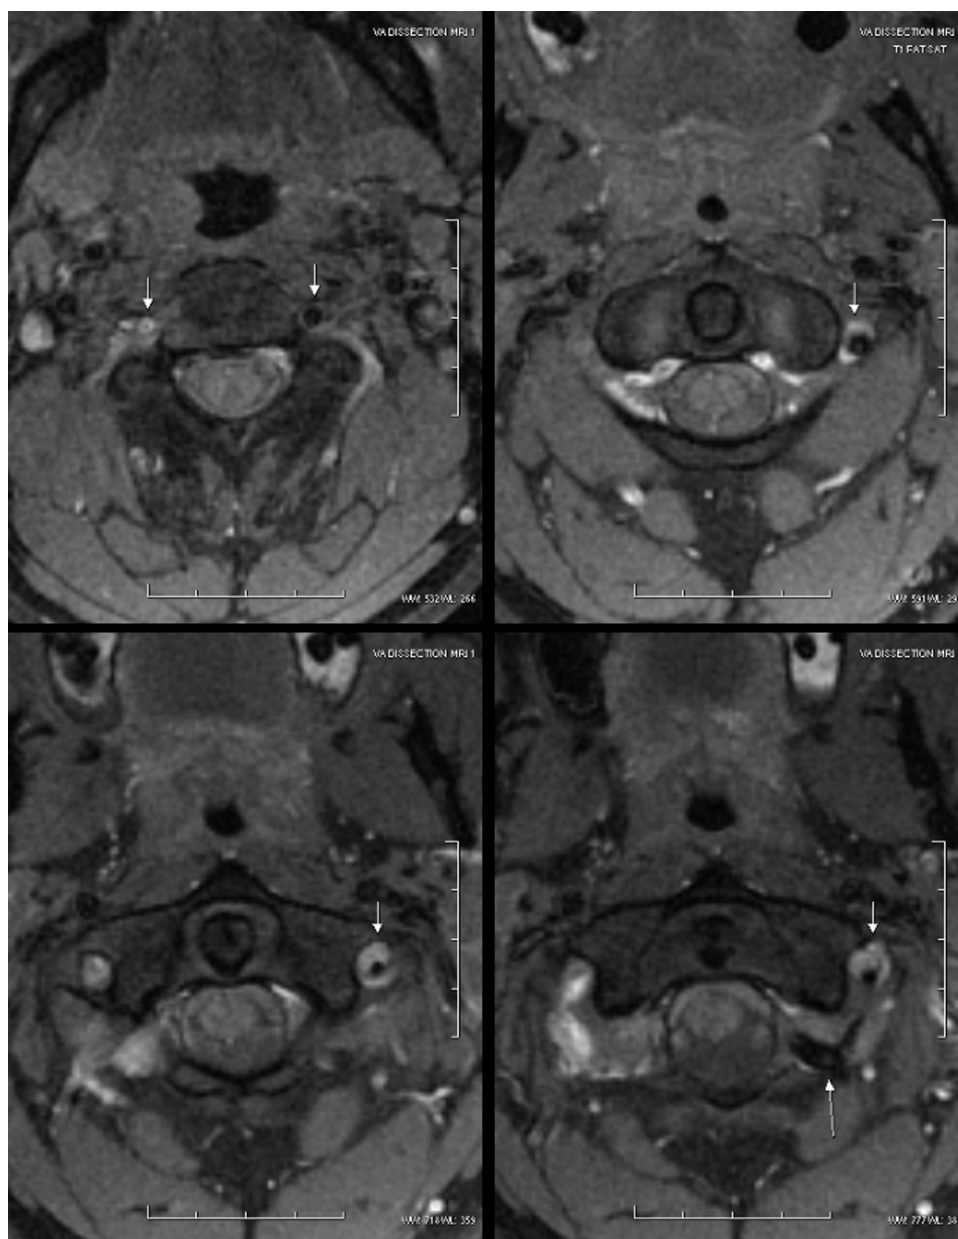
MR T1-weighted axial images with fat suppression (a)–(d). Hyperintensity of the vessel wall in both vertebral arteries consistent with the intramural hematoma (arrows). Loss of flow void signal in the right vertebral artery due to occlusion.
